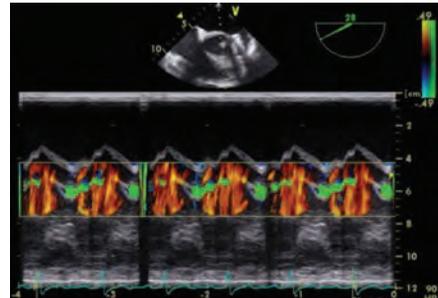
Transthoracic Echocardiography, color Doppler. No blood flow at systole and apparent flow in diastole within the "wind-sock".
